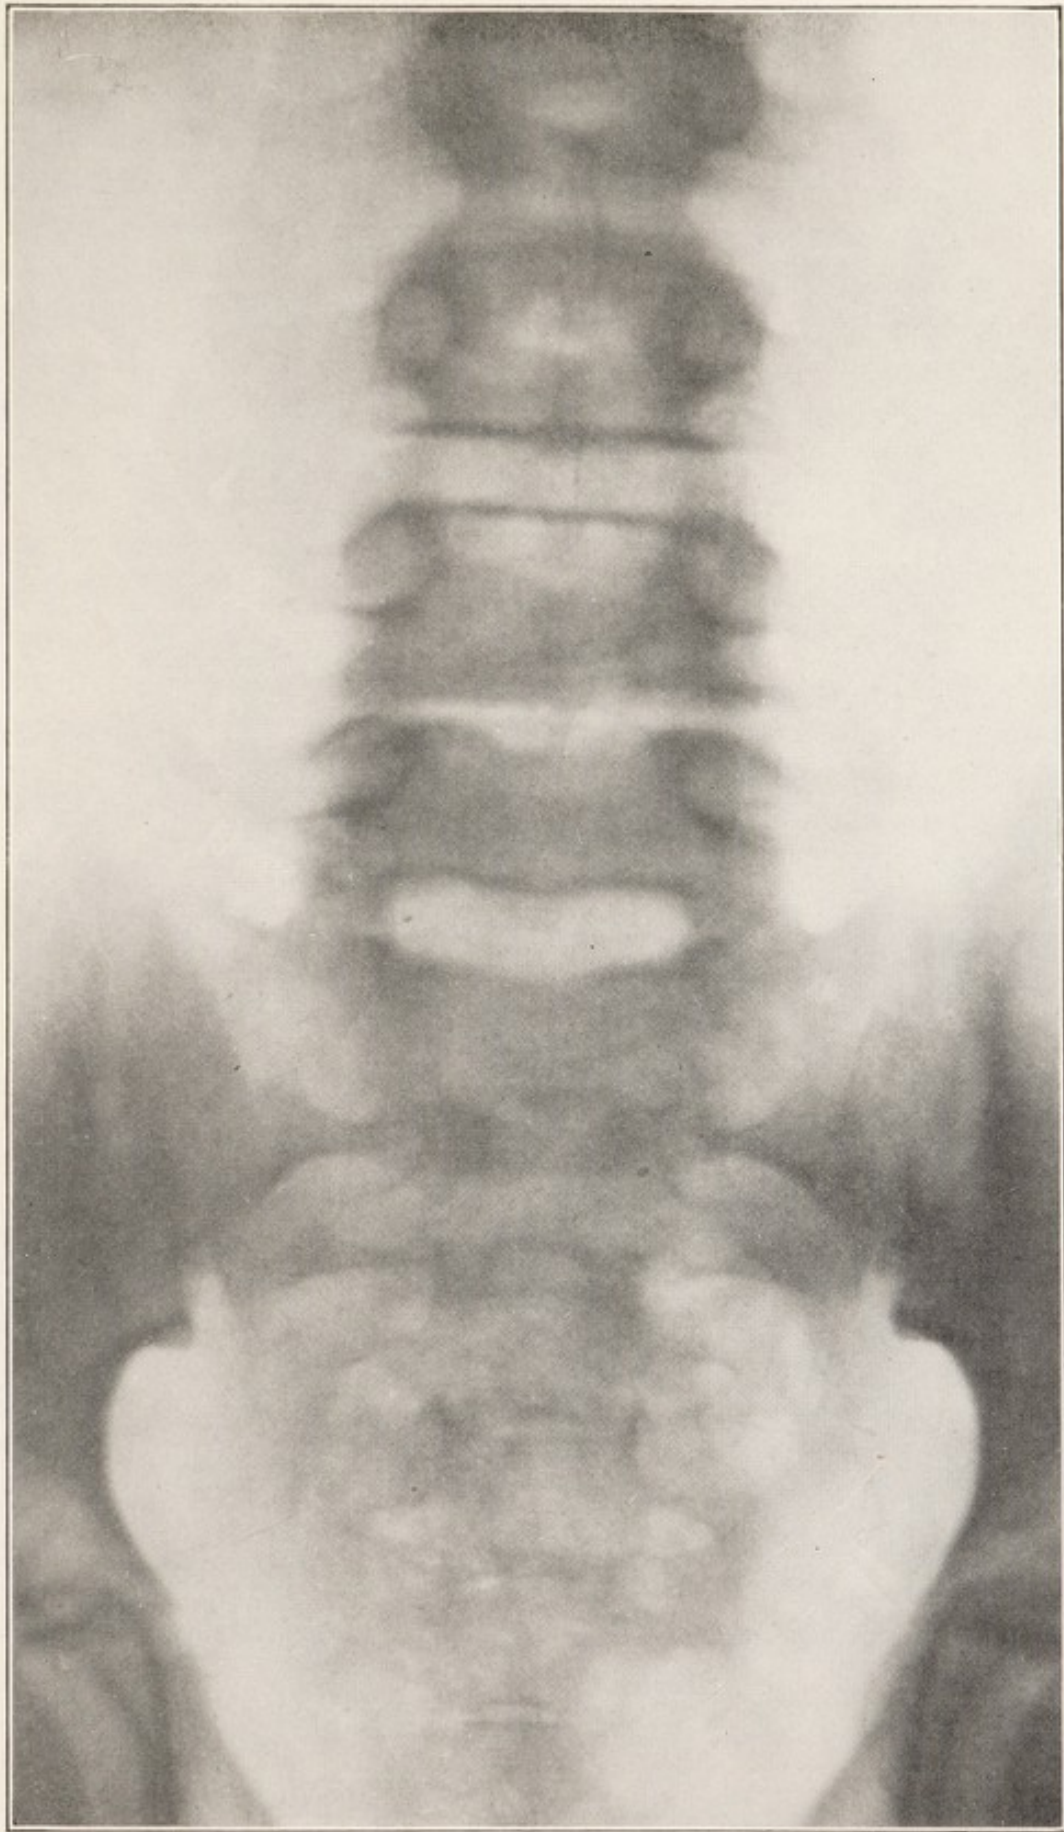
X-RAY SHOWING SUBACUTE INFECTIOUS SPONDYLITIS, WITH NARROWING OF INTERVERTEBRAL SPACE BETWEEN FOURTH AND FIFTH LUMBAR VERTEBRÆ, ANTEROPOSTERIOR VIEW.
